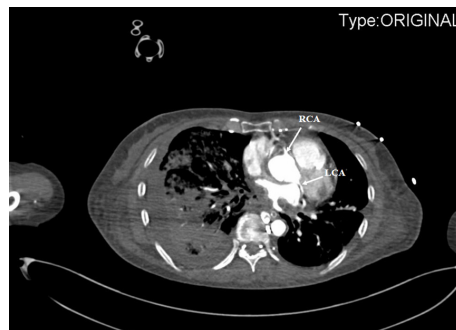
Contrast-enhanced CT scan showed the compression of soft tissues on the LMCA (A and B), as well as the right pulmonary artery (C), resulting in severe stenosis of these arteries. LAD, left anterior descending coronary artery; LCA, left coronary artery; LCX, left circumflex coronary artery; LMCA, left main coronary artery; LPA, left pulmonary artery; RCA, right coronary artery; RPA, right pulmonary artery
